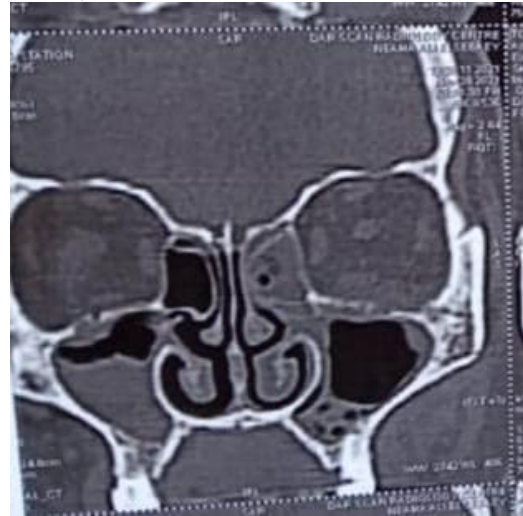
CT scan showing ethmoid and maxillary sinusitis with concha bullosa.
